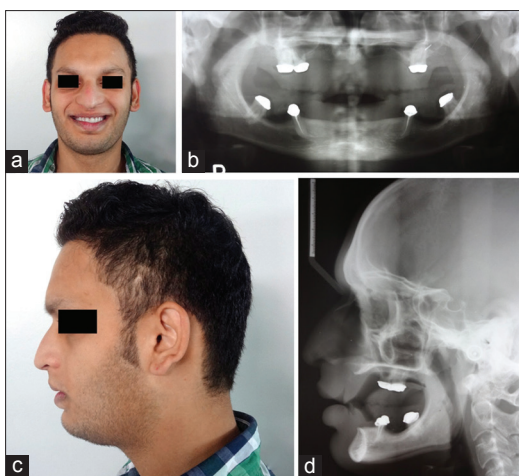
(a) Post-treatment facial view; (b) post-treatment panoramic radiograph; (c) post-treatment lateral profile view; (d) post-treatment lateral cephalograms. All showing improvement in the facial esthetics and functional rehabilitation of patient
